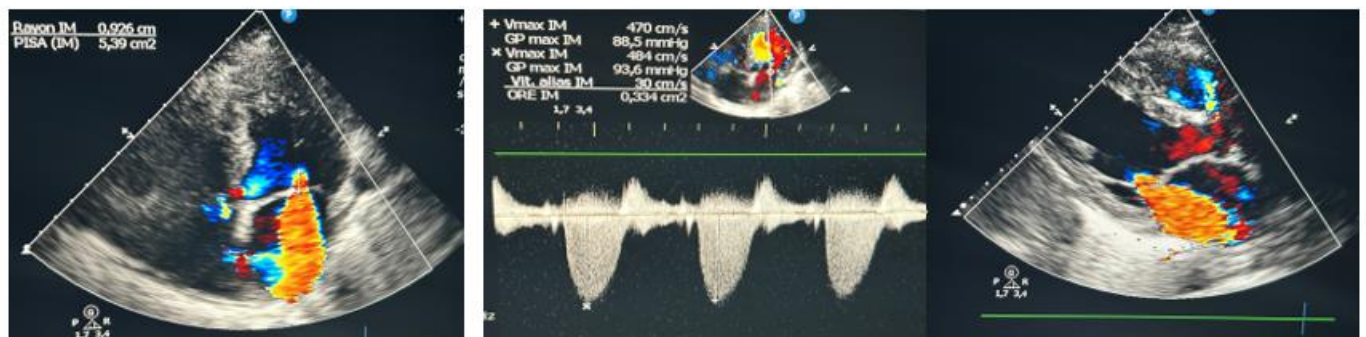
This 77-year-old patient was admitted with post-MI angina in inferior position, extended to the right shunts at H24, complicated by cardiogenic PAO. Echocardiography showed acute mitral insufficiency, on segmental hypokinetic cardiopathy with severe 30-35% LV dysfunction.
